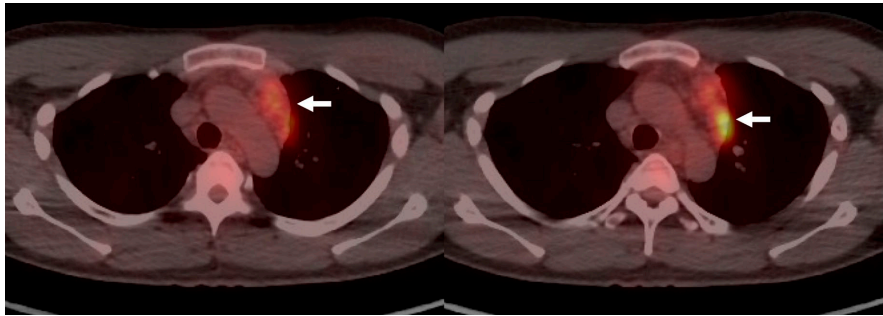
FDG PET/CT demonstrated the increased FDG uptake of anterior mediastinal lesions (arrow).
